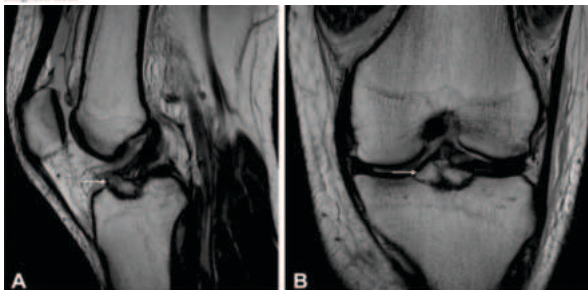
A type V bony avulsion (arrow) is seen on the (A) sagittal T1-weighted view and (B) coronal T1-weighted view.
